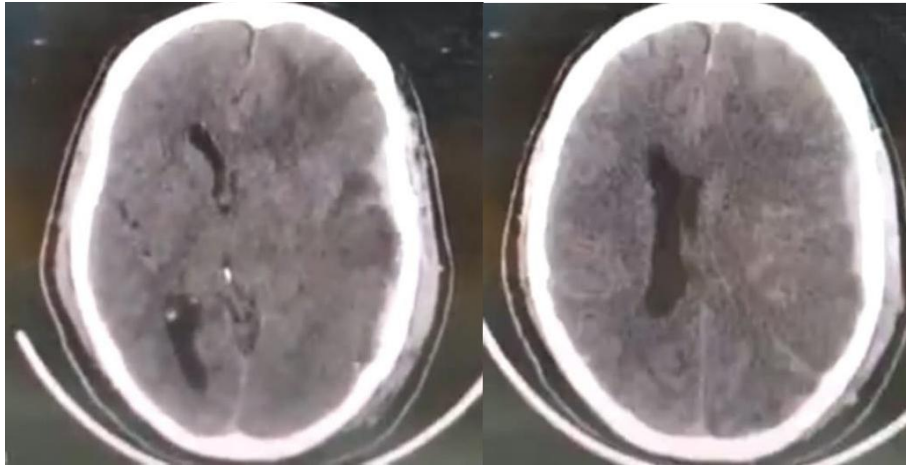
CT Brain showing midline shift and ventricular effacement and subarachnoid hemorrhage.
